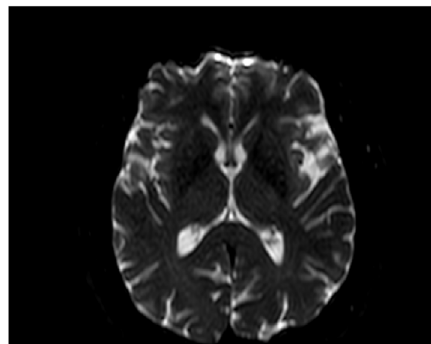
MRI Results. This figure shows the presence of the hyperintense (white) lesions in the left cerebral peduncle and posterior right parietal lobe.
